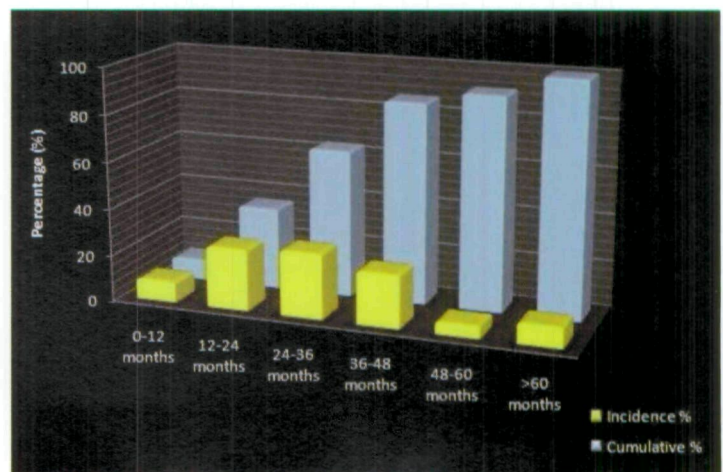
Distribution of radiographic failures (N=57) over time.
